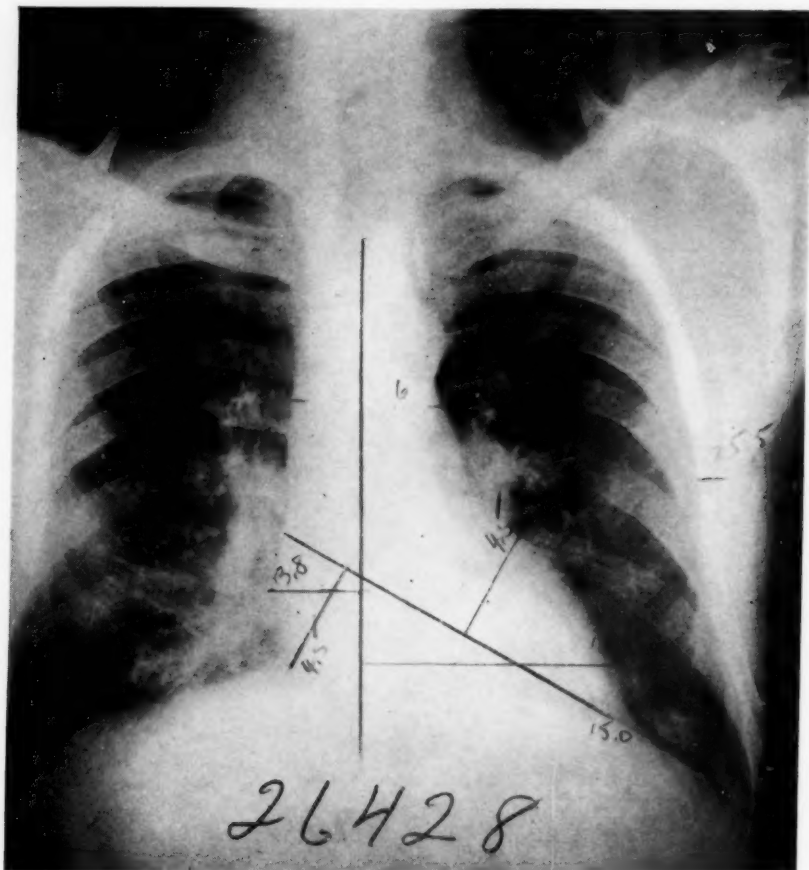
Roentgenograph of chest of S. B., made October 24, 1932, during a period of quiescence of infection.
